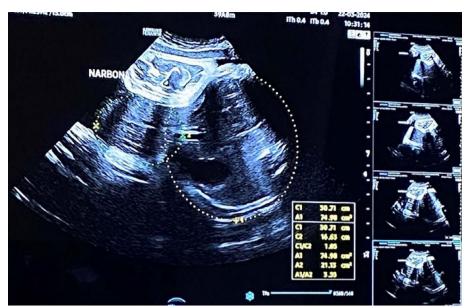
Prenatal ultrasonography: giant hepato-omphalocele.
